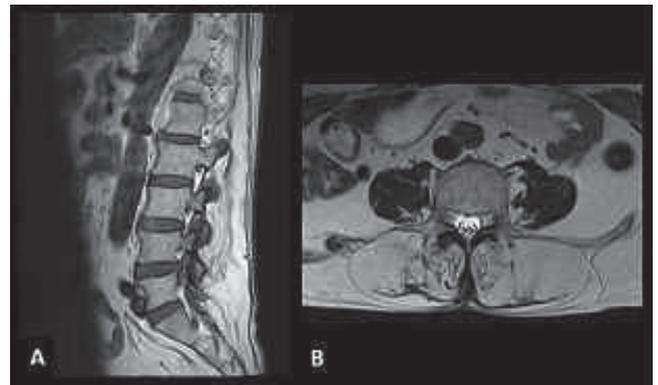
Magnetic resonance imaging of the thoracolumbar area shows significant replacement of the paravertebral muscles by fat in the lumbar area. (A) A sagittal T1 scan and (B) an axial T2 scan show a remarkable increase in adipose tissue in the paravertebral muscles characterised by increased signal intensity in the T1 and T2 images. Rare remaining fibres are represented by thin isosignal lines.
